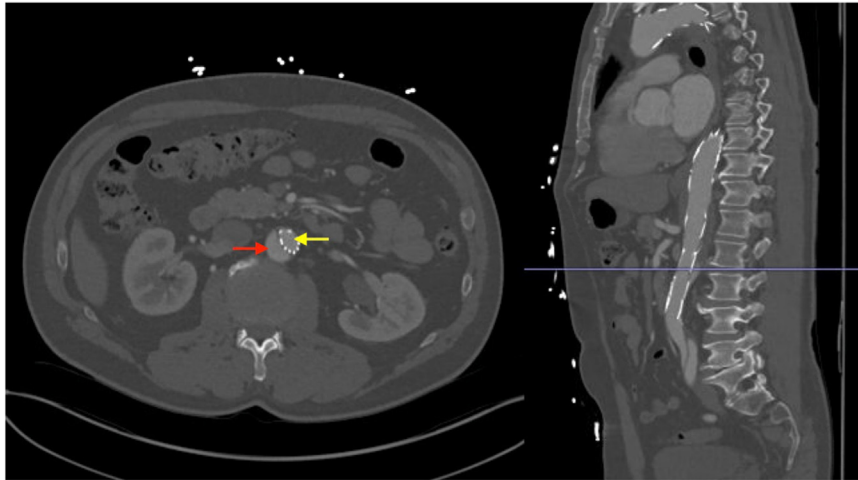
Preoperative computed tomography scan demonstrating narrowing of the true lumen (*yellow arrow*) in the infrarenal aorta within the previously placed bare metal stents. At this level, the true lumen measures 1.2×1.9 cm, and the false lumen (*red arrow*) measures 1.3×2.4 cm.
